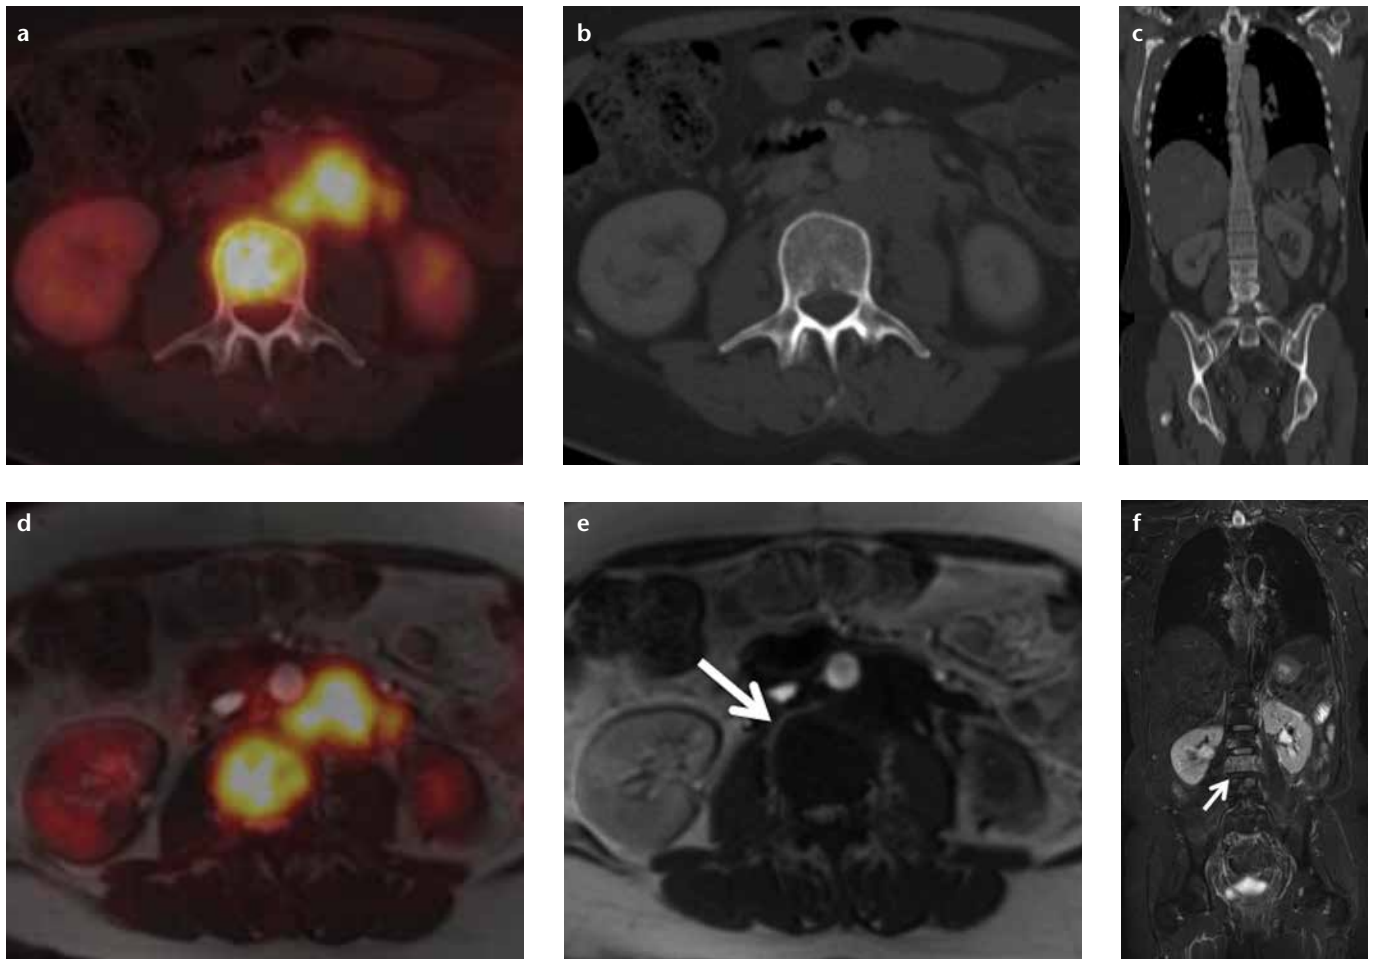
a–f. A patient with bone metastases originating from ovarian cancer and local bone marrow infiltration in the lumbar spine. While in FDG-PET/CT (a–c) the bone marrow infiltration is only detectable in PET (a) and shows no osseous destruction in CT (b, c), in FDG-PET/MRI (d–f) the infiltration is detectable both in PET (d) and in MRI due to a low signal in T1-weighted sequences (e, arrow) and high signal in T2-weighted sequences (f, arrow). Especially in patients undergoing chemotherapy bone metastases/bone marrow infiltrates might not be FDG-avid and therefore not detectable in PET/CT. In this case PET/MRI might represent an advantage in whole-body imaging.
